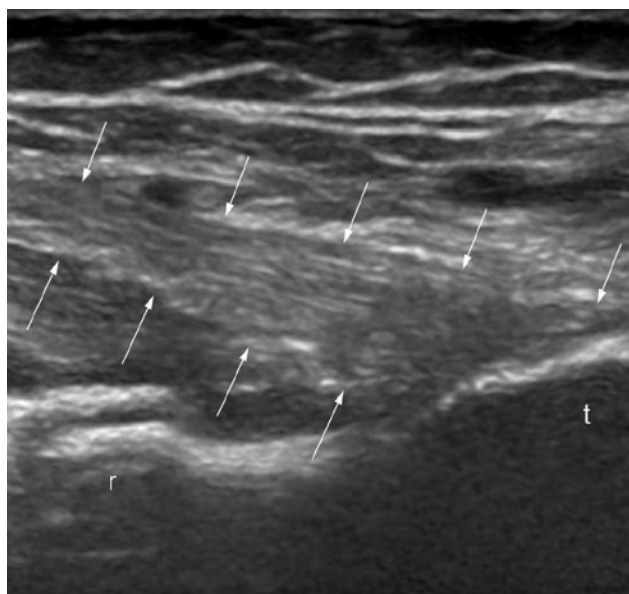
Longitudinal ultrasonographic view of a normal biceps tendon (arrows) inserting on the radial tuberosity (t). Radial head (r).
